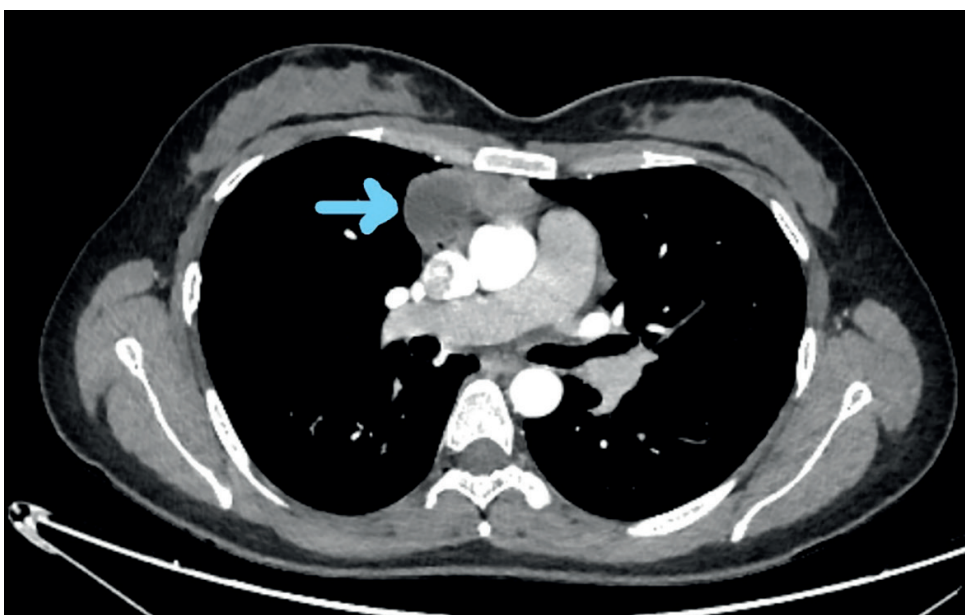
Preoperative computed tomography image showing a multilocular solid cystic lesion in the anterior mediastinum (arrow).
